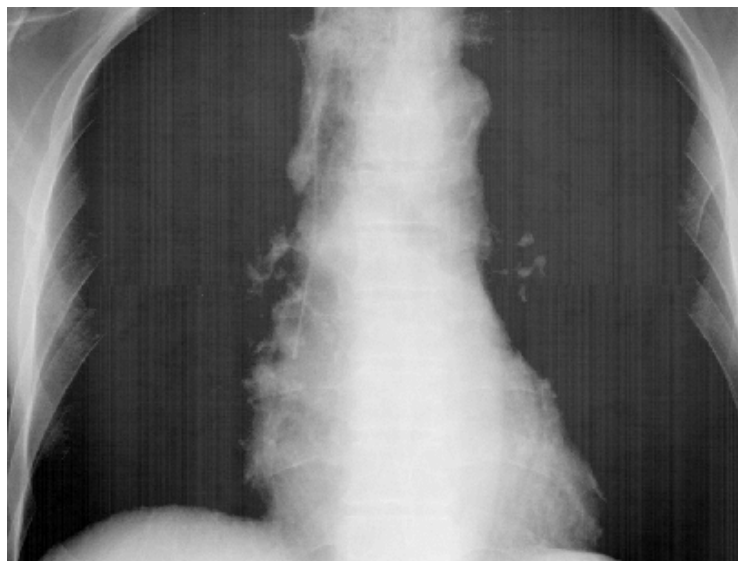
An anterior chest radiograph shows how detector saturation can compromise image matching by eliminating anatomical structure information from the image.
